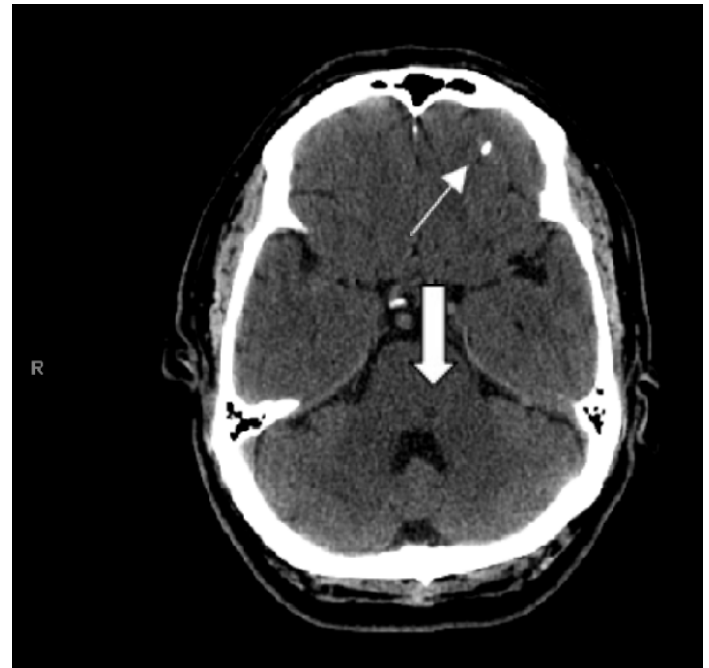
CT head without contrast done 48 hours from admission showing a small ill-defined hypodensity in the left dorsal lower pons/upper medulla consistent with lacunar infarct (*thick arrow*), and an ectatic left vertebral artery. A small metallic foreign body is still seen in the left orbital region (*thin arrow*).
